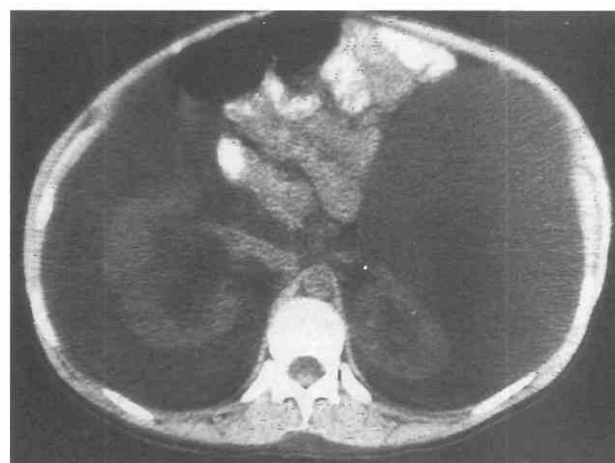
Renal lymphangiectasia in a 25-year-old woman who experienced severe abdominal distention during pregnancy. An unenhanced CT scan shows large bilateral perinephric lymph collections and renal sinus lymphatic cysts. (From Meredith WT, Levine E, Ahlstrom NG, Grantham JJ: Exacerbation of familial renal lymphangiomas during pregnancy. *AJR Am J Roentgenol* 151:965-966, 1988.)
